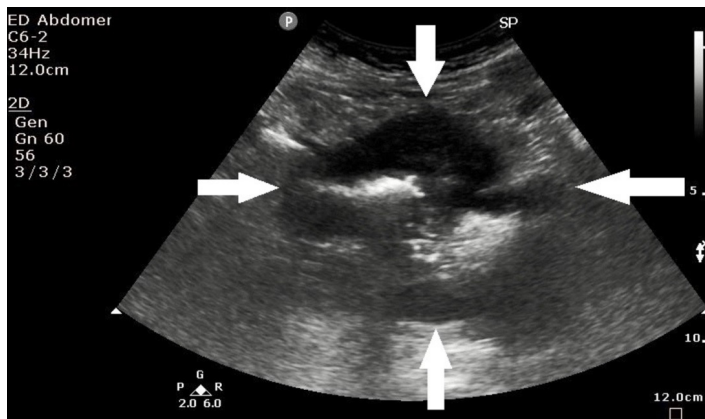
Point-of-care ultrasound of the left lower quadrant showing a suprapubic mass of mixed echogenicity with marginal halo as outlined by the white arrows, later determined to be a gastrointestinal stromal tumor.
